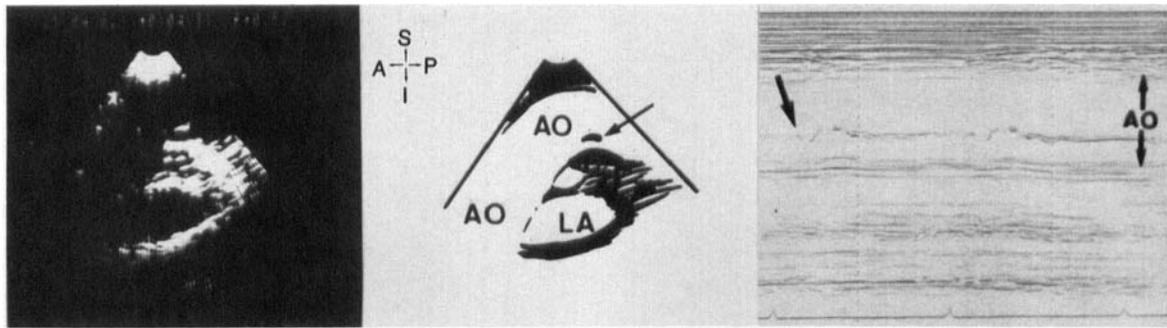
Example of a tricky case. On right parasternal long-axis view, we observed a very localized and short echo at the level of the aortic arch. The M-mode recorded simultaneously showed a minimally mobile linear echo. The diagnosis of aortic dissection was confirmed in this case by angiography. Ao: aorta, LA: left atrium, A: anterior, S: superior, P: posterior, I: inferior.
